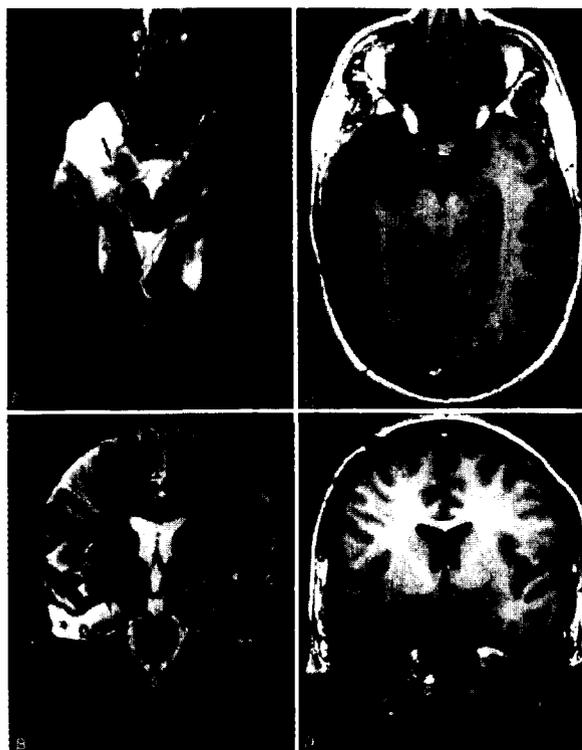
Neuroimaging in a patient who underwent anterior temporal lobectomy without improvement of his seizure disorder. A and B: Axial (A) and coronal (B) magnetic resonance images (TR 2100 msec, TE 30 msec). The residual amygdala is best seen in A (arrow), and the residual hippocampus is best seen in B. C and D: Axial (C) and coronal (D) magnetic resonance images (TR 523 msec, TE 19 msec) after reoperation showing resection of the above structures. The patient is seizure-free after reoperation.
